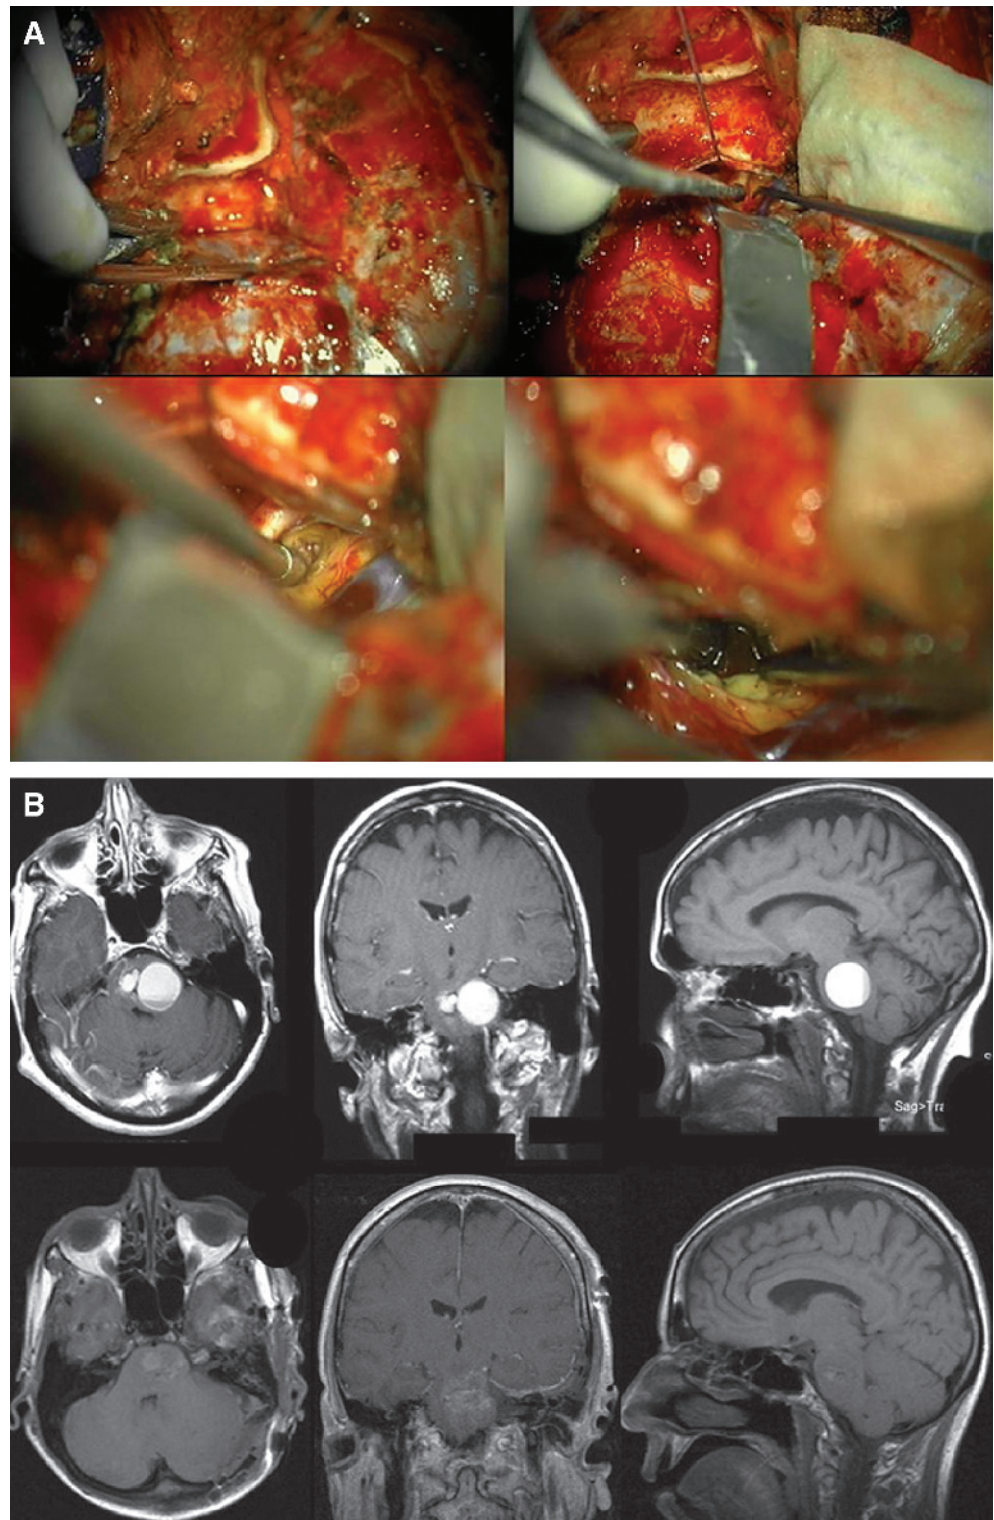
A, intraoperative photographs of petrosal approach to a brainstem cavernous malformation. Top left, left-sided approach showing bony removal in front of the sigmoid sinus. Top right, dural opening in front of the sigmoid sinus to preserve the sinus and expose the ventrolateral brainstem. Bottom left, exposure of the discolored brainstem from the cavernous malformation. Bottom right, removal of the malformation in a piecemeal fashion. B, top, preoperative MRI showing pontine cavernous malformation resected through a petrosal approach. Bottom, postoperative MRI documenting complete resection of the lesion.
